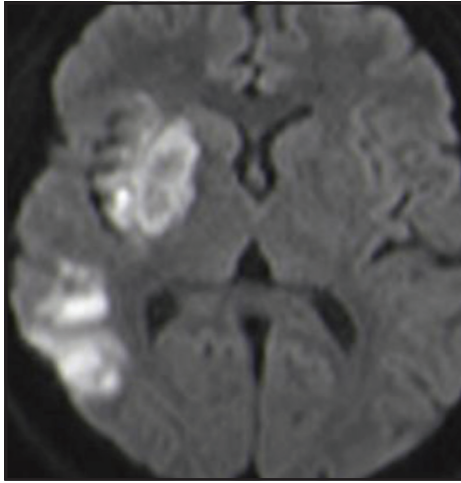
MRI DWI Brain showing restriction in areas of infarct.
